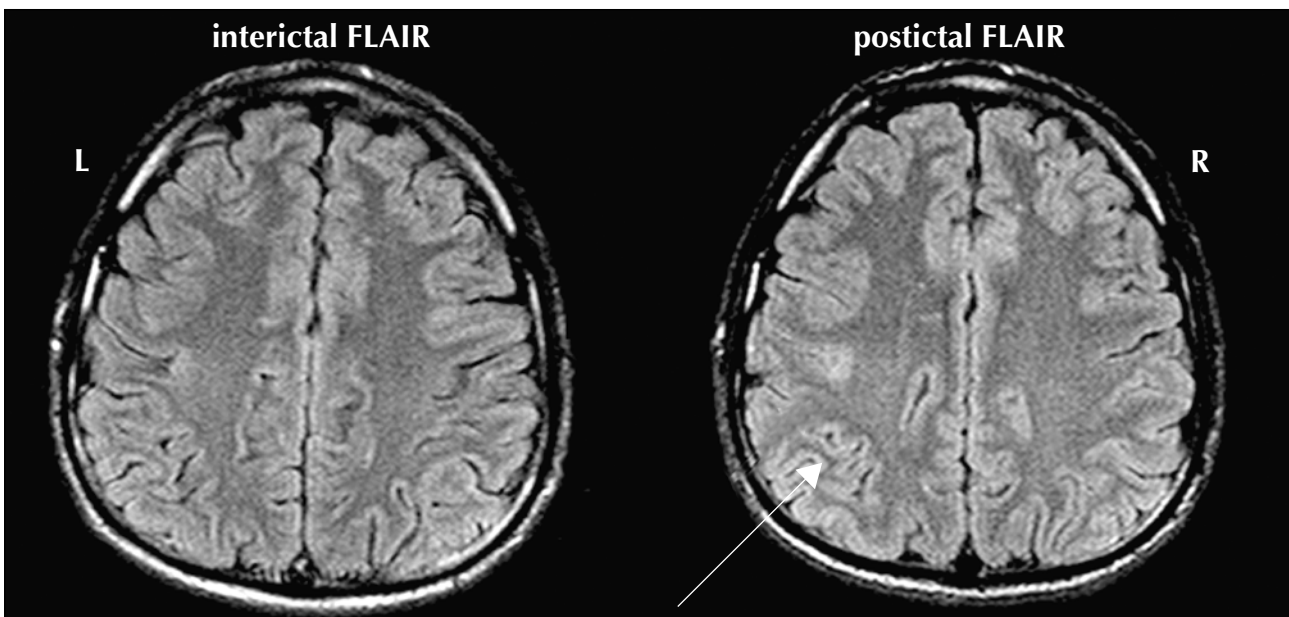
Focal increase in FLAIR signal intensity after the series of simple partial seizures (indicated with arrow).
